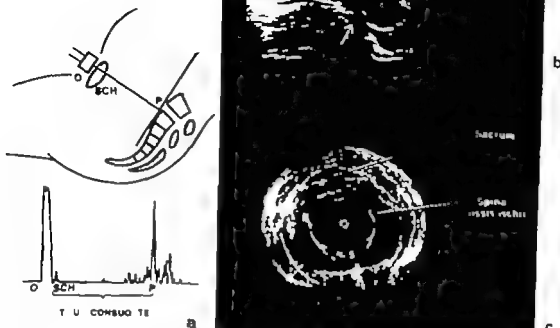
Methods for ultrasonic pelvimetry (a) left side of the picture measuring the true conjugate by the A-mode technique O=emitting signal, Sch=symphysis, P=promontory (b) outlining the promontory by longitudinal scan from the xyphoid sternum to the symphysals. The promontory and the symphyses are marked by arrows.
